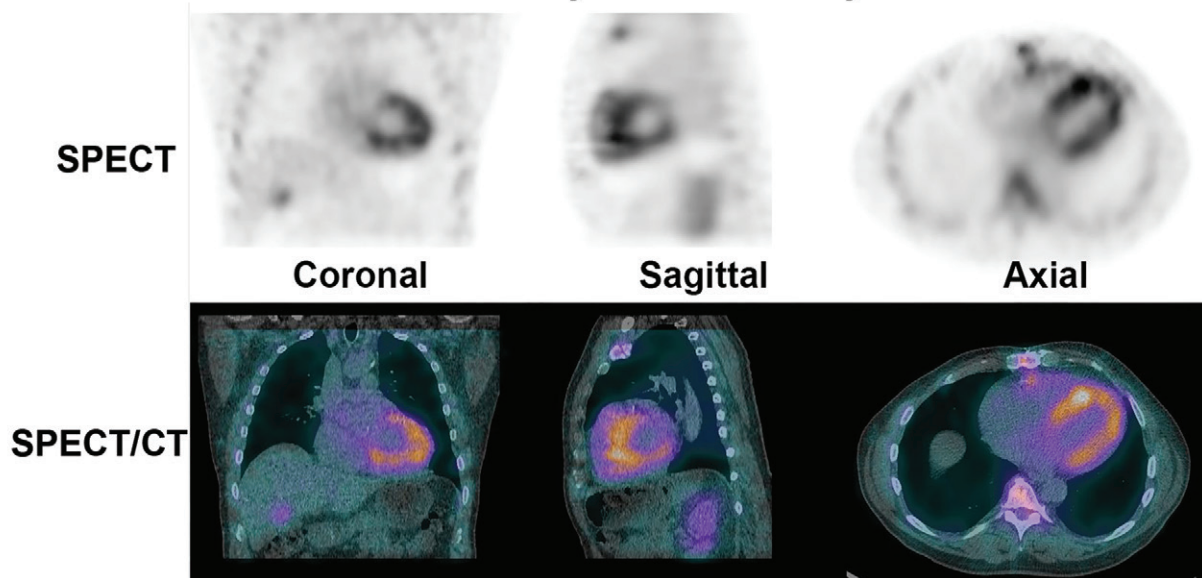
SPECT and SPECT/CT to distinguish myocardial technetium ^{99m}pyrophosphate uptake from blood pool activity. (A) On SPECT and SPECT/CT images, tracer activity in the blood pool has an amorphous appearance that is not clearly separable from the mediastinum. (B) True-positive tracer uptake by the myocardium is characterized by a U shape or horseshoe shape on the axial and coronal planes and a donut shape on the sagittal plane.
